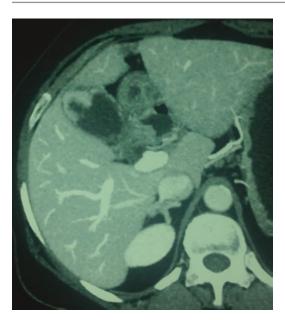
CT shows focal thickening of the gall bladder wall with no liver infiltration, i.e., a clear fat plane is seen between the GB wall and the liver parenchyma—extended cholecystectomy can be performed for gall bladder cancer, which is confined to the gall bladder wall
